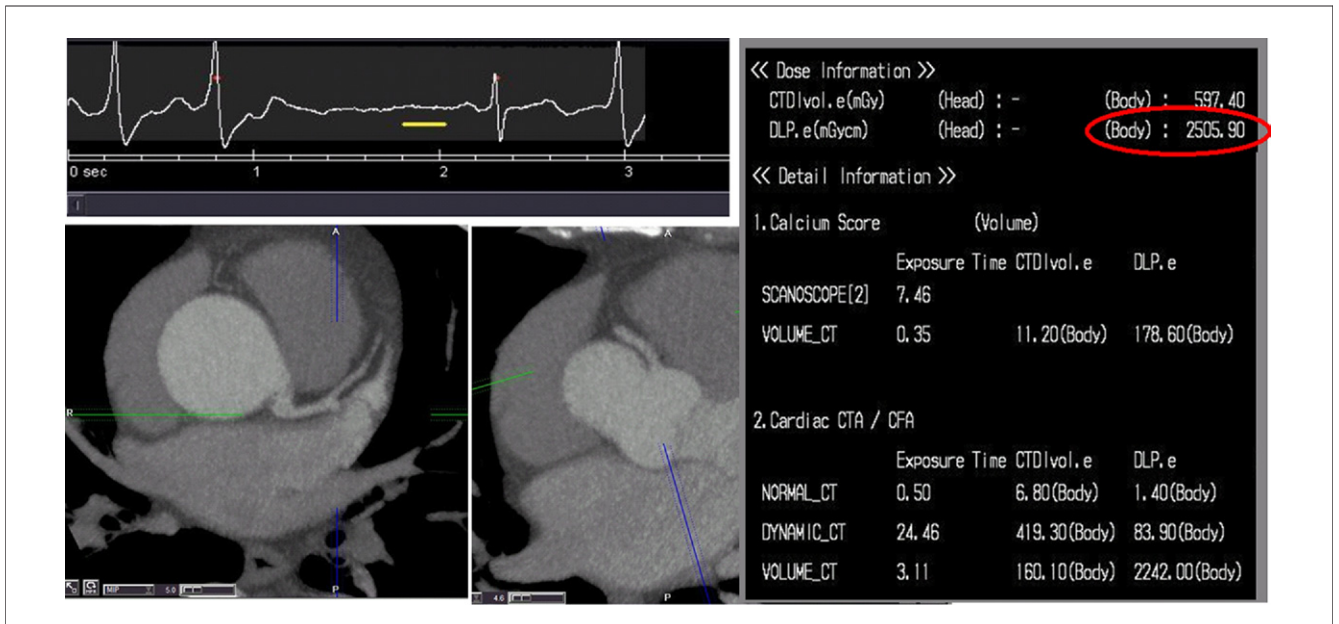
Coronary CT Angiogram Performed in a 64-Year-Old Obese Man With Atypical Chest Pain and Frequent Ventricular Ectopy
